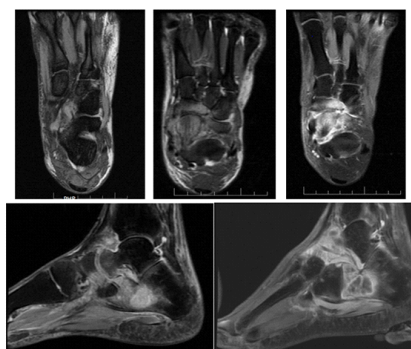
28year old female presented with pain in the left ankle and treated case of pulmonary koch's , H/o trauma 1 year back, MRI with contrast reveals, Multiple intraosseous and extra osseous pockets of infective collection are seen in and around calcaneum, talus and navicular bones causing moth eaten lytic destruction of calcaneum, talus and navicular bones. Extensive Synovitis with mild to moderate joint effusion seen involving ankle joint, subtalar joints, intertarsal and metatarso-tarsal joints with enhancing periarticular inflammatory soft tissue around the involved joints – Features are of tubercular arthritis.
